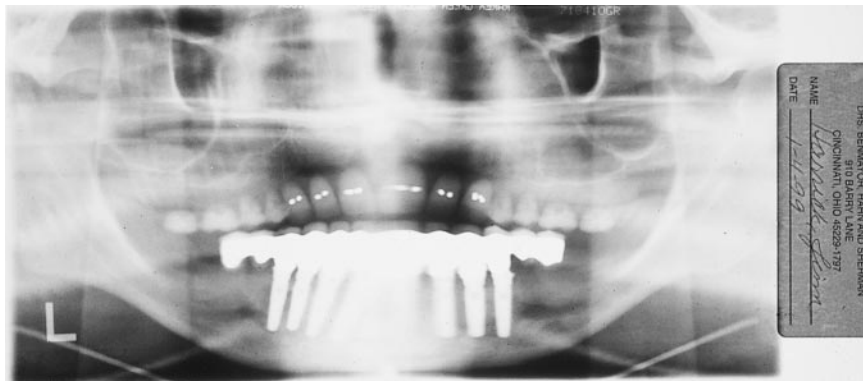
Panoramic radiograph of the completed implants and restoration.
